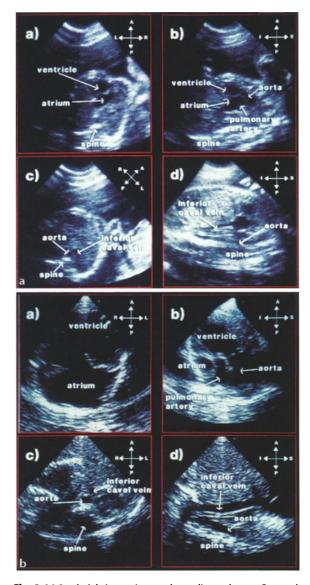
Atrial isomerism: echocardiography. a Prenatal echocardiography at 27 weeks of gestation, showing a common atrium connected through a common atrioventricular valve to a ventricle of right morphology (a), giving origin to both the great arteries with the aorta anterior to the pulmonary artery and subpulmonary obstruction (b); the short-axis view shows that the inferior vena cava and the abdominal aorta are on the same side of the spine, with the vein anterior and to the left of the artery (c and d), arrangement consistent with right isomerism, b neonatal echocardiography of the same subject as in a, with short-axis view confirming the prenatal echocardiographic diagnosis (reproduced with permission from: Rossi G, Corno AF, Montemurro G (1992) Prenatal diagnosis of isomerism of the right atrial appendages. Cardiol Young 2:298–301)
